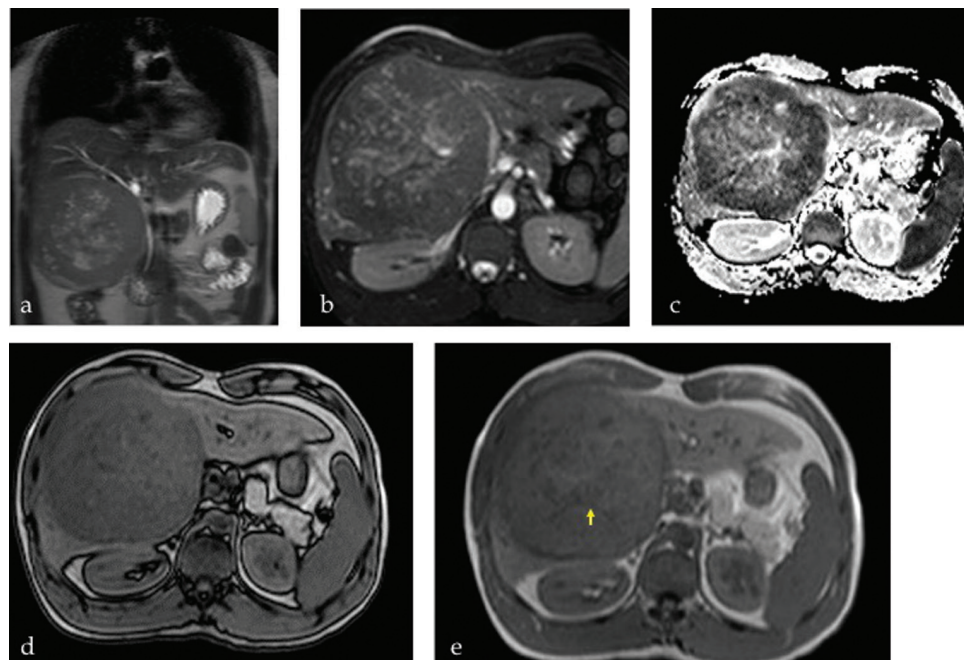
Hepatocellular carcinoma on magnetic resonance imaging. a and b. T2W images show a large heterogeneous mass. c. Apparent diffusion coefficient map demonstrates marked restriction of diffusion. d. In and (e) out of phase images show a small focus of fat with signal drop on out of phase (arrow).
